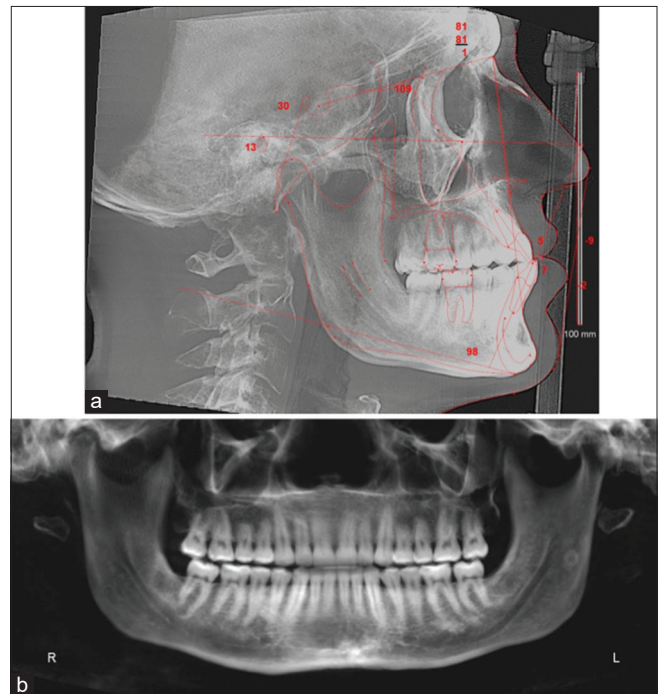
Pretreatment radiographs. (a) Lateral cephalometric radiograph with tracing. (b) Pretreatment panoramic radiograph
